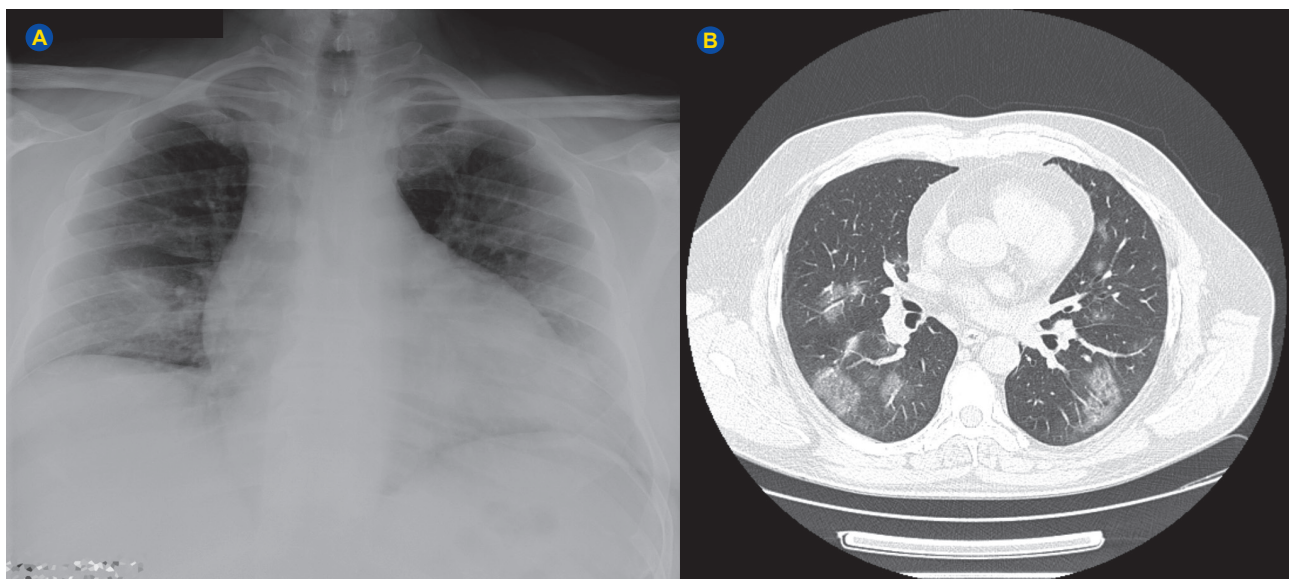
52-year-old hypertensive male patient attends the emergency department due to persistence of fever and diarrhea for six days. Lab work performed at admission reveals leucopenia, thrombocytopenia and increased lactate dehydrogenase levels. Chest radiography (A) and thoracic CT axial slice (B) performed at admission show multiple bilateral peripheral ground-glass opacities, compatible with COVID-19 pneumonia, which was confirmed with throat and nasal swab test.
